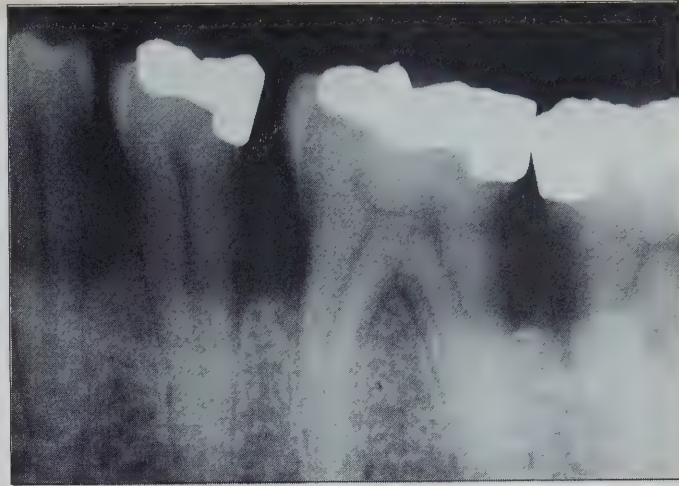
Radiograph of the mandibular left posterior region displaying horizontal bone loss and overhanging amalgam restorations.
